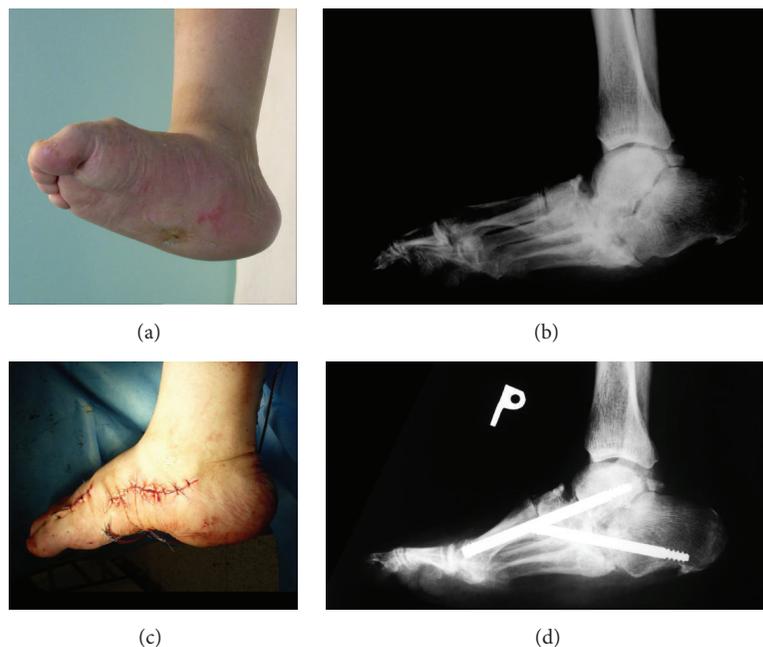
(a) Clinical image of CN with collapsed middle part of tarsus and plantar sinus (right foot). (b) Preoperative X-ray image of collapsed arch in the middle part of tarsus. (c) Clinical image immediately after reconstruction with reconstructed longitudinal arch. (d) Lateral X-ray image demonstrates reconstruction of both columns two months after surgery.
